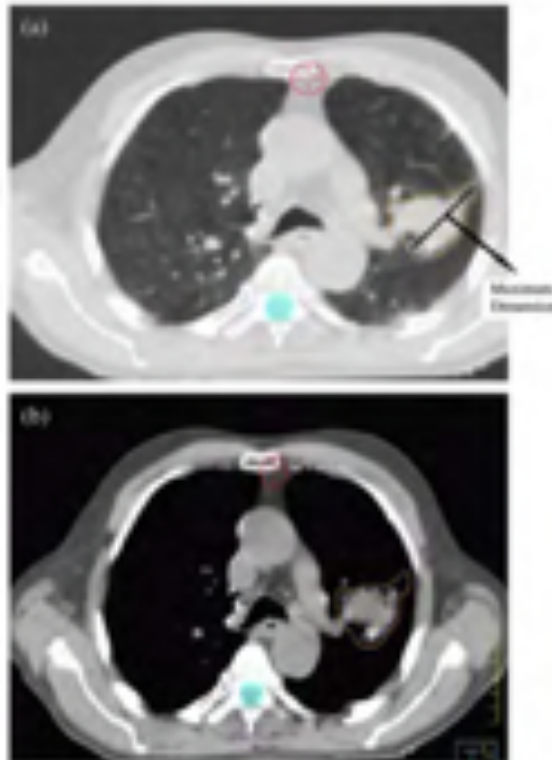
(a) Maximal tumor size as measured on computed tomography (CT) lung windows. (b) Maximal tumor size by CT lung windows vs. CT mediastinal/sub-tissue windows. Outer contour represents maximal tumor size as measured on CT lung windows; inner contour represents maximal tumor size as measured on CT sub-tissue windows.
